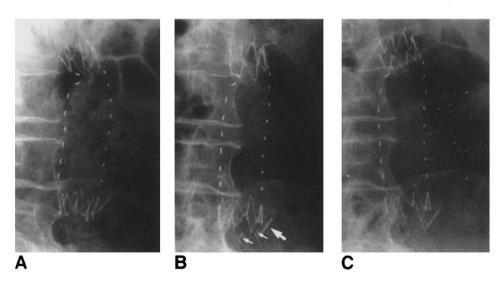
Serial plain abdominal radiographs suggest probable migration of distal attachment system in patient with AAA rupture 2.5 years after endoluminal repair. A, Six-month radiograph. B, Two-year radiograph. Two strut fractures are present in the distal attachment frame (*small arrows*) and the attachment system is higher relative to calcified plaque in the distal AAA wall (*large arrow*). C, Two and one-half year radiograph 2 weeks before rupture. Attachment system appears further separated from fractured hooks and area of calcification. No contrast leak was evident on CT scan.
